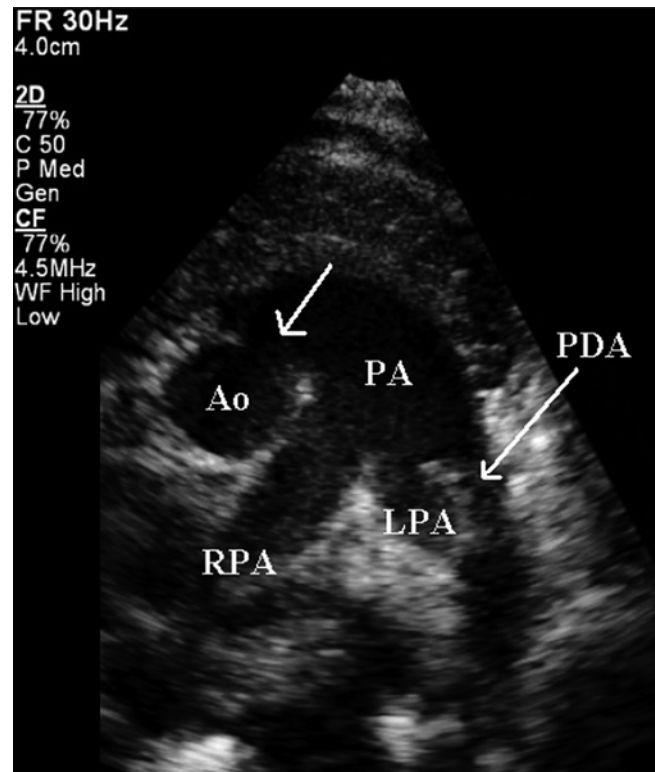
Echocardiogram with a high right parasternal short axis view demonstrating an aortopulmonary defect (arrow depicts) between the descending aorta and main pulmonary artery. Ao aorta, PA pulmonary artery, RPA right pulmonary artery, LPA left pulmonary artery, PDA patent ductus arteriosus
